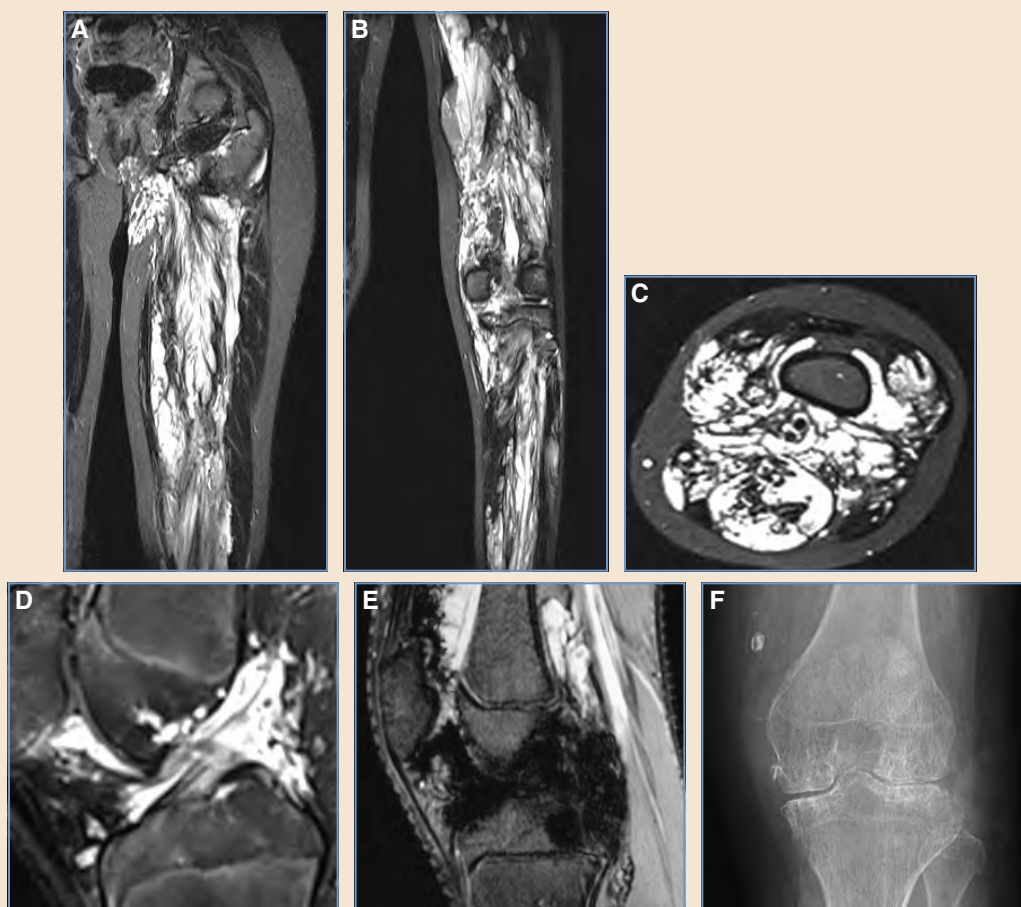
Diffuse lower extremity venous malformation. A-C, T2-weighted MRI sequences show diffuse intramuscular involvement throughout the lower extremity with intraarticular venous malformation. D, Cruciate ligaments are enveloped by the articular venous malformation. E, Gradient echo MRI sequence shows hemarthrosis. Hemosiderin appears as artifact with black areas of signal loss on gradient echo sequences. F, Severe arthropathy can result from recurrent hemarthroses.
